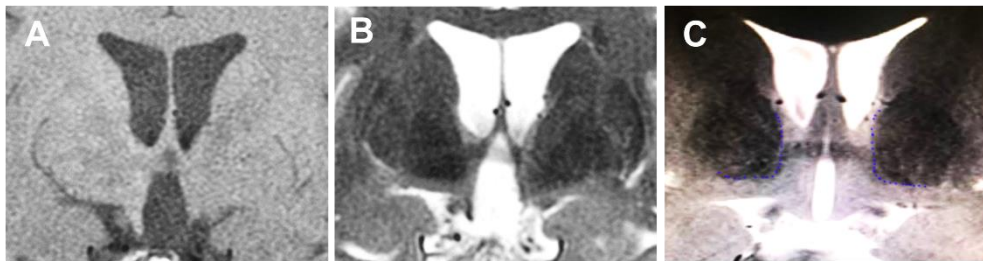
Example of method 1 (T1-weighted images)
